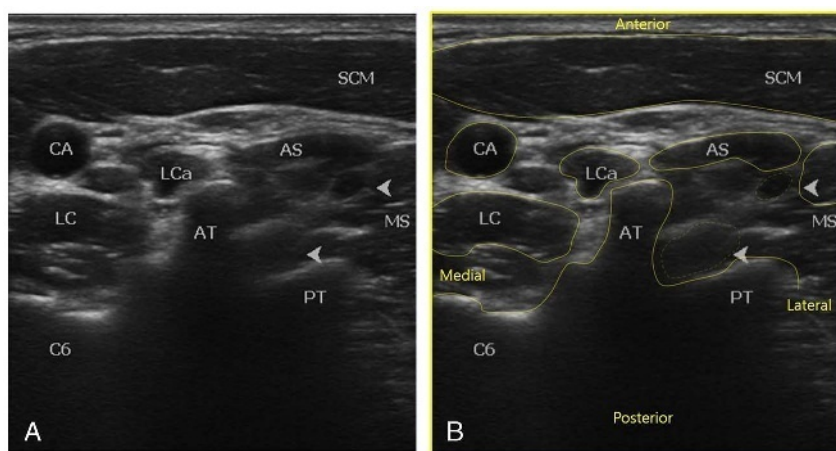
Transverse sonographic image at the level of C6 showing the prominent anterior tubercle. CA indicates carotid artery; SCM, sternocleidomastoid; LC, longus colli; LCa, Longus capitus; AS, anterior scalene; MS, middle scalene; AT, anterior tubercle; PT, posterior tubercle; C6, C6 vertebral body. Arrowheads point to C6 and C5 roots.
